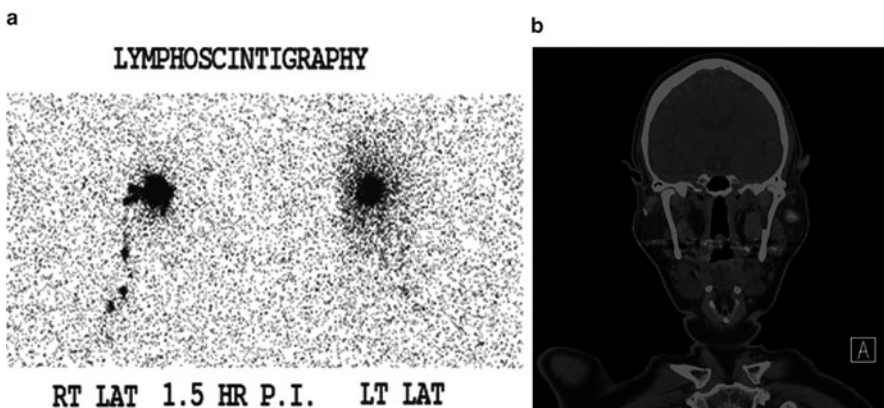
(a) Preoperative lymphoscintigraphy shows drainage to a parotid node. (b) SPECT/CT scan provides a higher resolution and anatomic detail for the draining node(s). Note the enhancing node in the left parotid area
